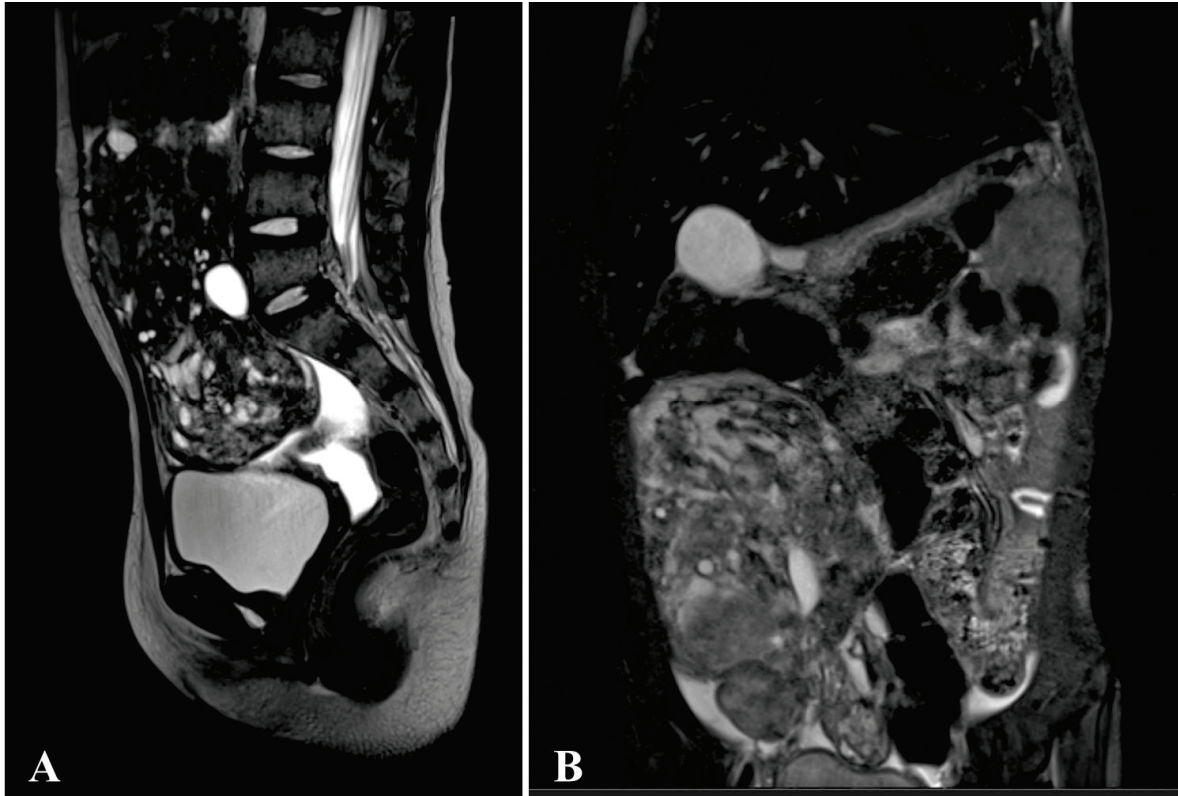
MRI of patient from case N° 5 ((A)—T2WI sag, (B)—T2 FS cor): massive pelvic tumor with intra-abdominal spread. The tumor has a cystic-solid structure with expansive growth. The upper pole of the tumor reaches the visceral surface of the liver, the lower pole pushes aside the bladder, right kidney, bowel loops, and inferior vena cava.
